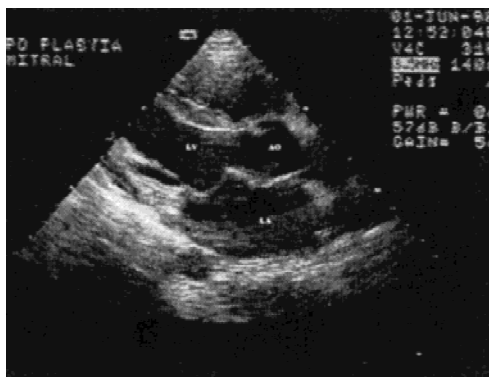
Parasternal long-axial view of the left ventricle (LV) (systole frame) depicting a prolapse of leaflets still present (patient No. 11; see Table 1). AO, aorta; LA, left artery.
